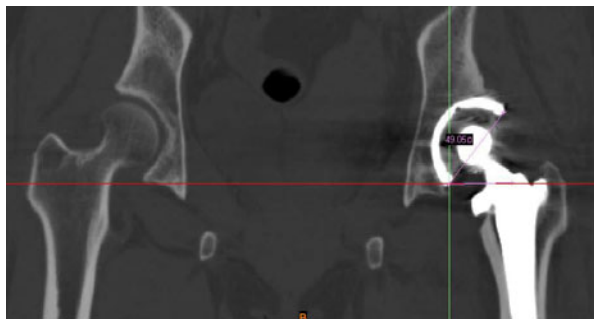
Postoperative CT scan for abduction angle of acetabular prosthesis
